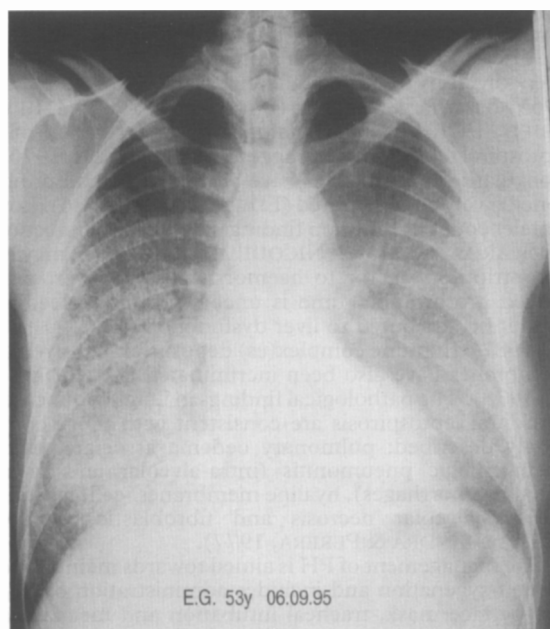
Radiograph of the chest in Case 3 showing bilateral multiple lung infiltrates.
